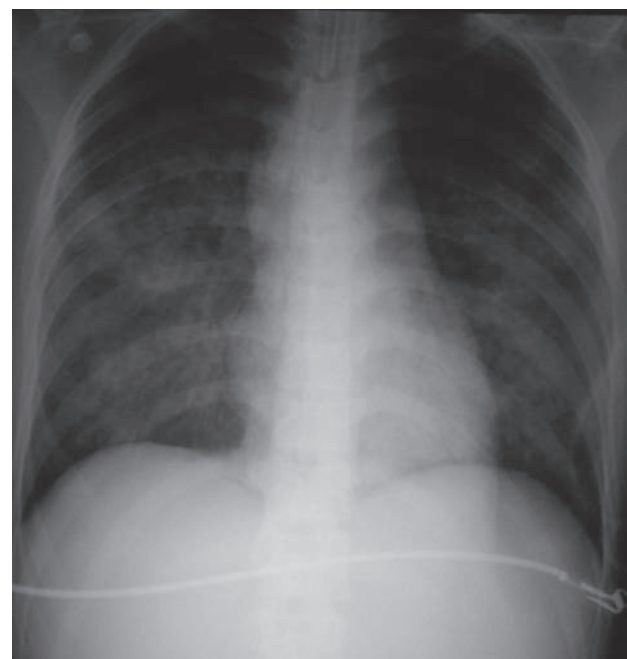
The chest x-ray film showed improvement of bilateral alveolar edema on post-operative day 1.
